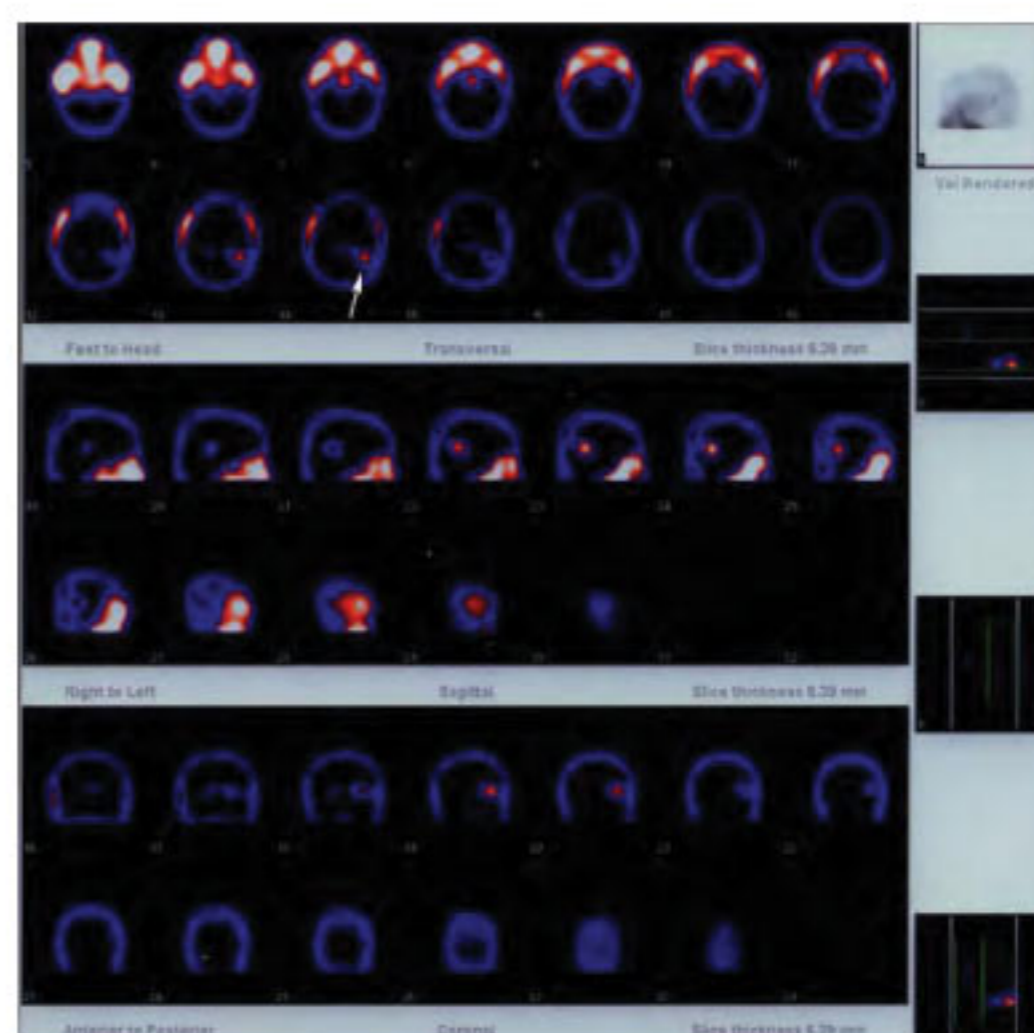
A 35 years old woman with grade II astrocytoma. The lesion displays fair ^{99m}Tc -tetrofosmin uptake on SPET scintigraphy (arrow). The tracer UI obtained was 3.1.
